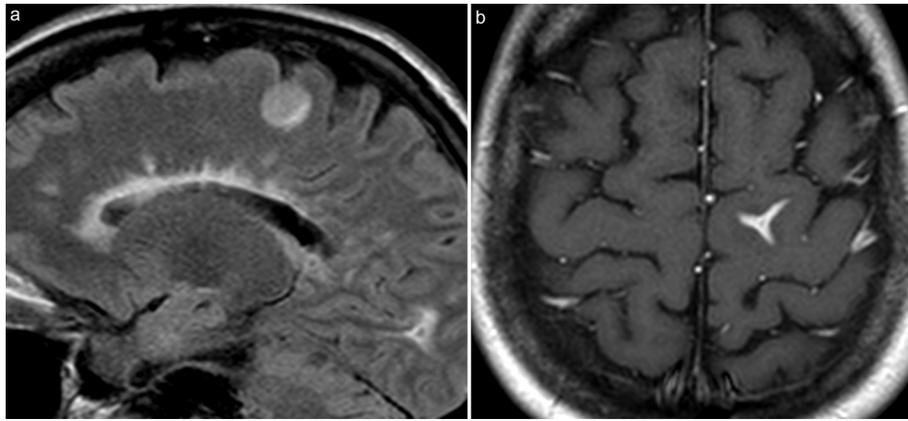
(a) Sagittal T2-weighted FLAIR and (b) axial T1-weighted post-contrast images demonstrate cortical and juxtacortical T2 hyperintense lesions with enhancement morphology atypical for actively demyelinating lesions.
